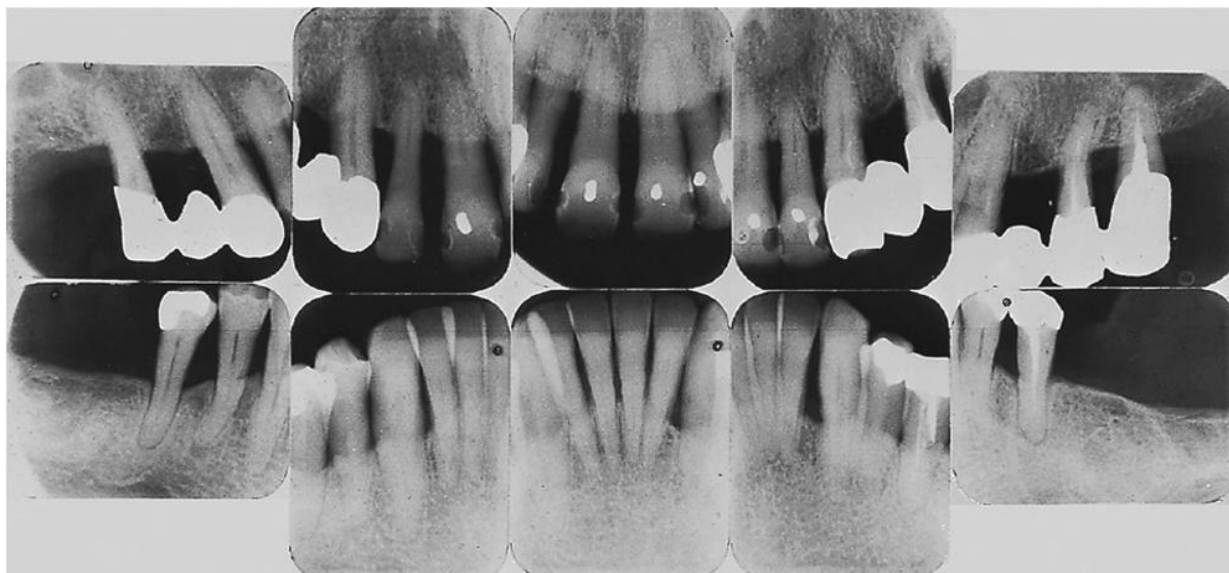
Case A, 64-year-old male. Radiographs prior to therapy.
